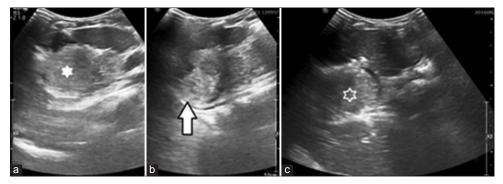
Ultrasound abdomen of the patient. (a) Axial section of the stomach region shows an echogenic mass ball with well defined margins with foci of air trapping (white star), (b) sagittal section shows the same mass (white arrow) without extension from any of the surrounding structures, (c) mobile echogenic ball abutting against the pylorus junction (white star)
